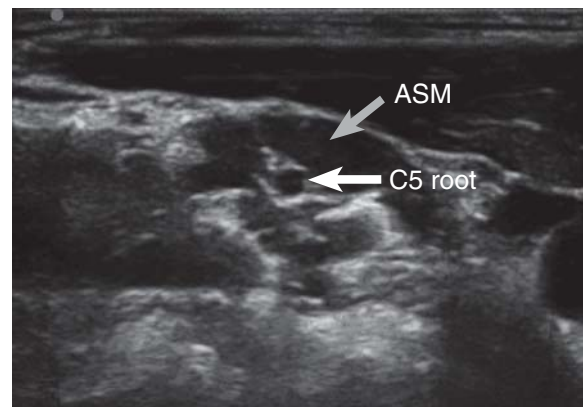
Cross-sectional ultrasound view of the brachial plexus at the interscalene level in which the C5 root is located within the anterior scalene muscle (ASM; right side, medial).
